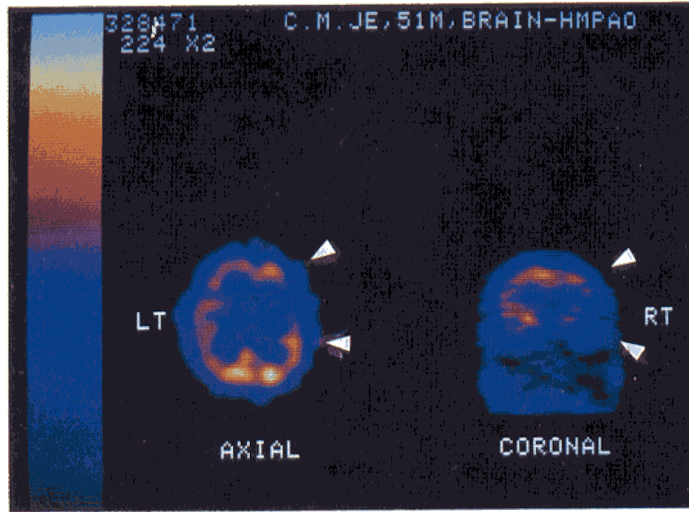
HM-PAO brain SPECT image of the Patient 1 demonstrated decreased rCP in the frontal, temporal, and parietal cortex, ipsilateral to the thalamic lesion.
